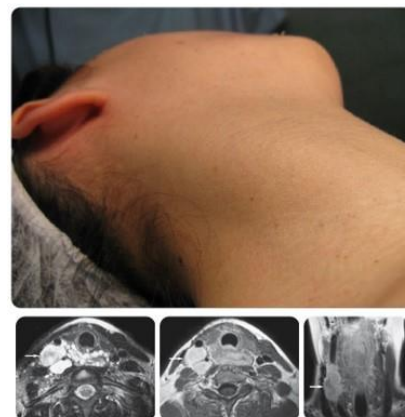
MRI: T2-weighted images with high-signal-intensity myxoid material peripherally and a relatively low-signal-intensity fibrous component centrally. The reverse target sign may be present on T1-weighted images after IV administration of gadolinium-based contrast material, characterized by enhancement of the central fibrous component and a relative lack of enhancement of the surrounding myxoid component. Right Vagus Plexiform neurofibroma.
